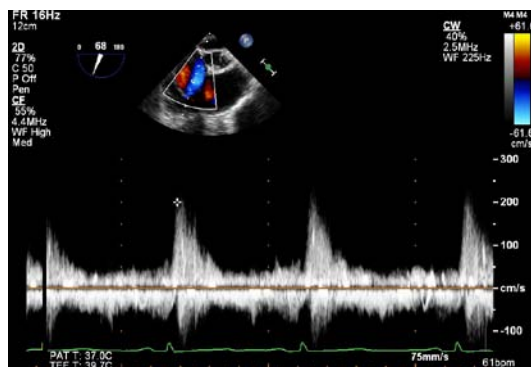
Mild tricuspid regurgitation on continuous wave Doppler (103)
